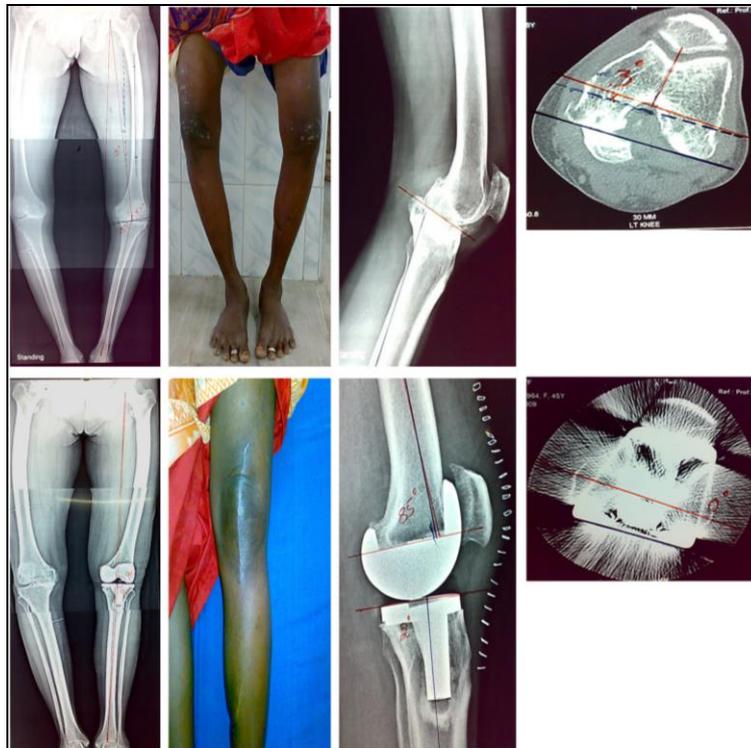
shows a 45/F presented with osteoarthritis left knee. Her preoperative knee score was 55. She underwent left sided TKA and had knee score of 86 at follow up. The results were graded as excellent with anatomical restoration of the components which was confirmed by post op CT.
